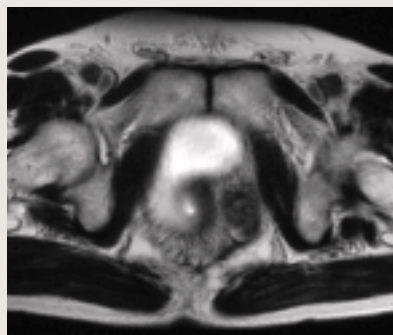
T2-weighted image
